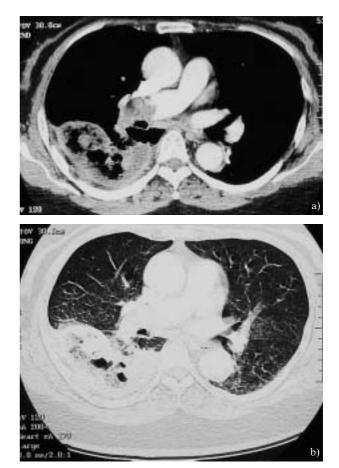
Computed tomography scans of the chest 7 days after cholecystectomy. a) The mediastinal window at the level of the aortopulmonary window and b) the parenchymal window at the level of the lower lung fields.
